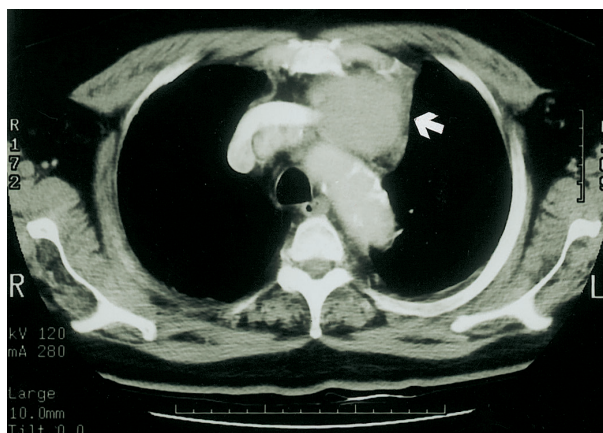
CT scan demonstrating an anterior mediastinal mass (white arrow).
